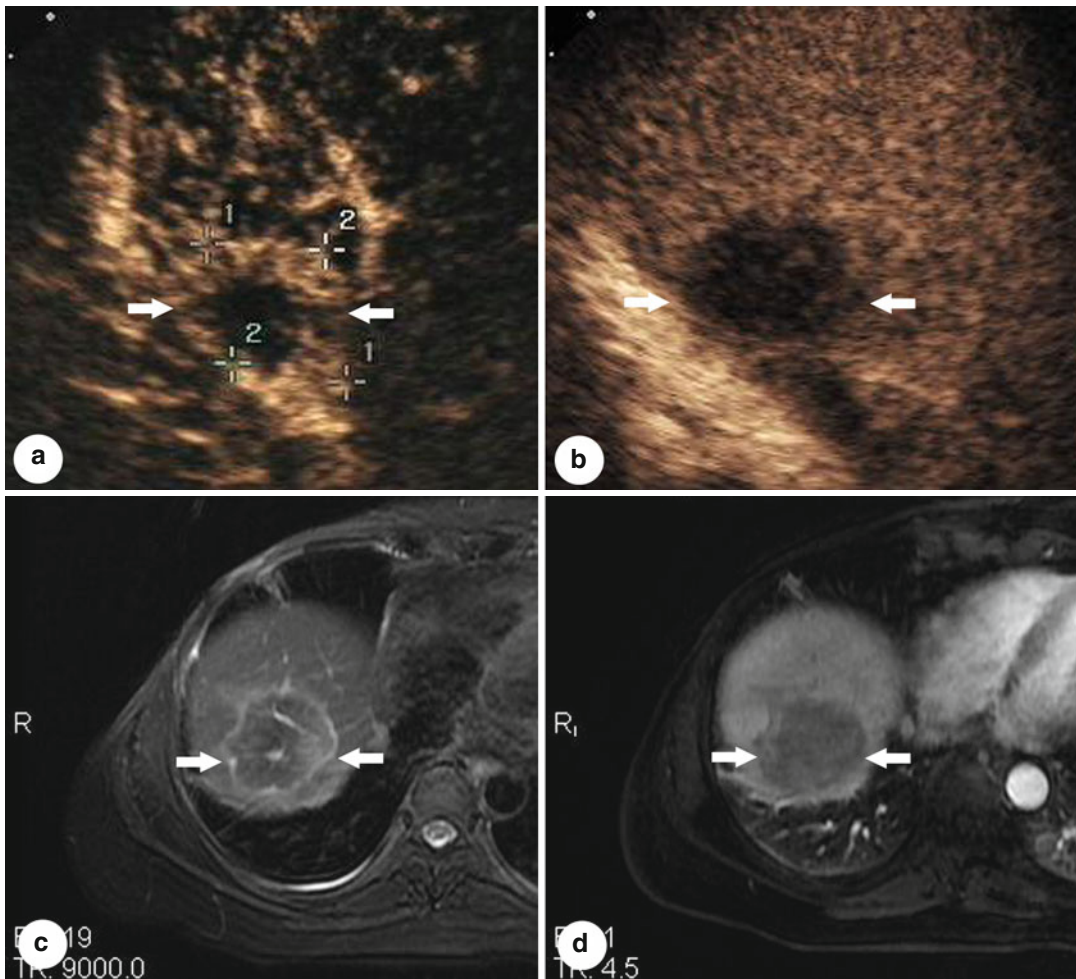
Presentations of a hepatic epithelioid hemangioma in hepatic segment VIII of a 47-year-old female patient on ultrasound (US) and magnetic resonance imaging before and after microwave ablation (MWA). The patient had a history of radical resection of the breast 1 year ago, and the diagnosis of the lesion was doubtfully malignant on enhanced imaging before ablation. The diagnosis was pathologically proven by biopsy under US guidance. (a) Contrast-enhanced US showed the lesion with a maximum diameter of 24 mm
